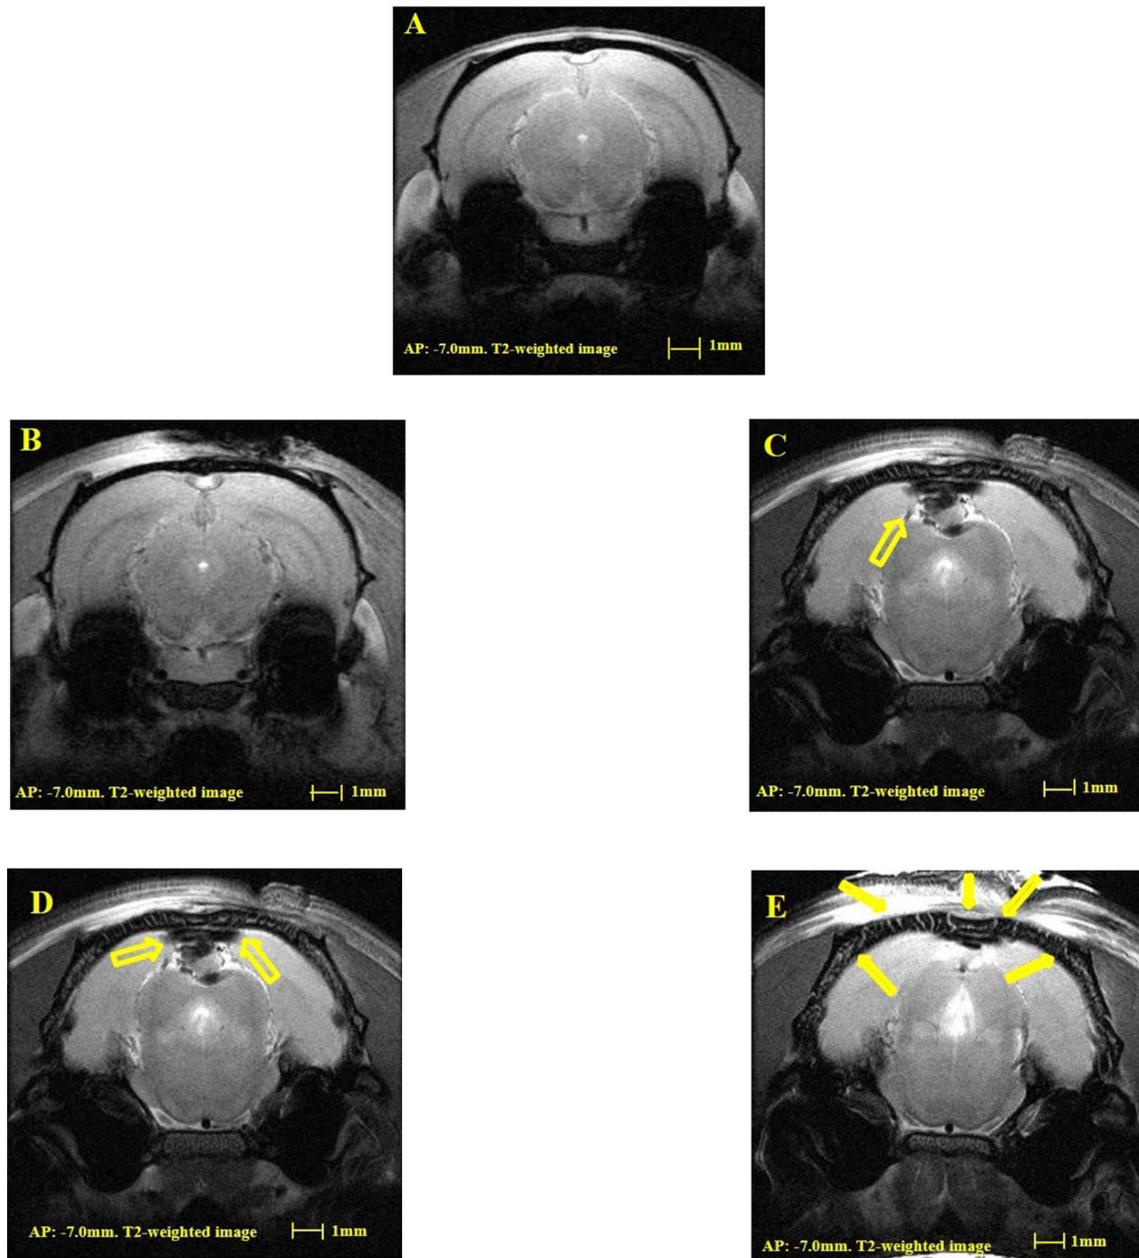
a T2-weighted MRI of normal control (NC), b T2-weighted MRI of TBI from 0.5 m, c T2-weighted MRI of TBI from 1 m, d T2-weighted MRI of TBI from 1.5 m. e T2-weighted MRI of TBI from 2 m. Arrows shows the severity of TBI and cerebral edema
